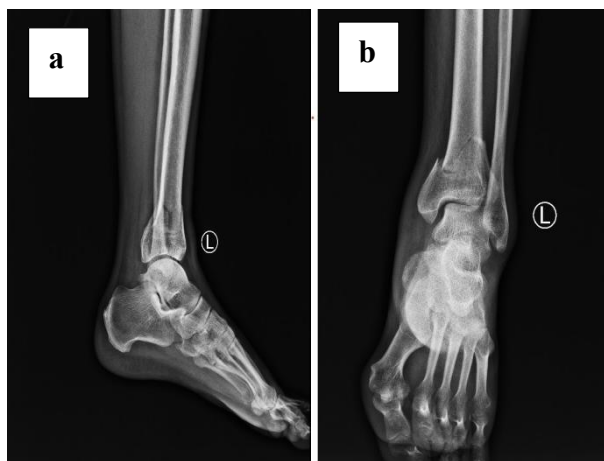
Preoperative X-ray imaging data. a The lateral view of the left ankle shows a clear fracture of the tibia involving the distal tibial articular surface; b The anteroposterior view of the left ankle reveals a distinct fracture line in the tibia
